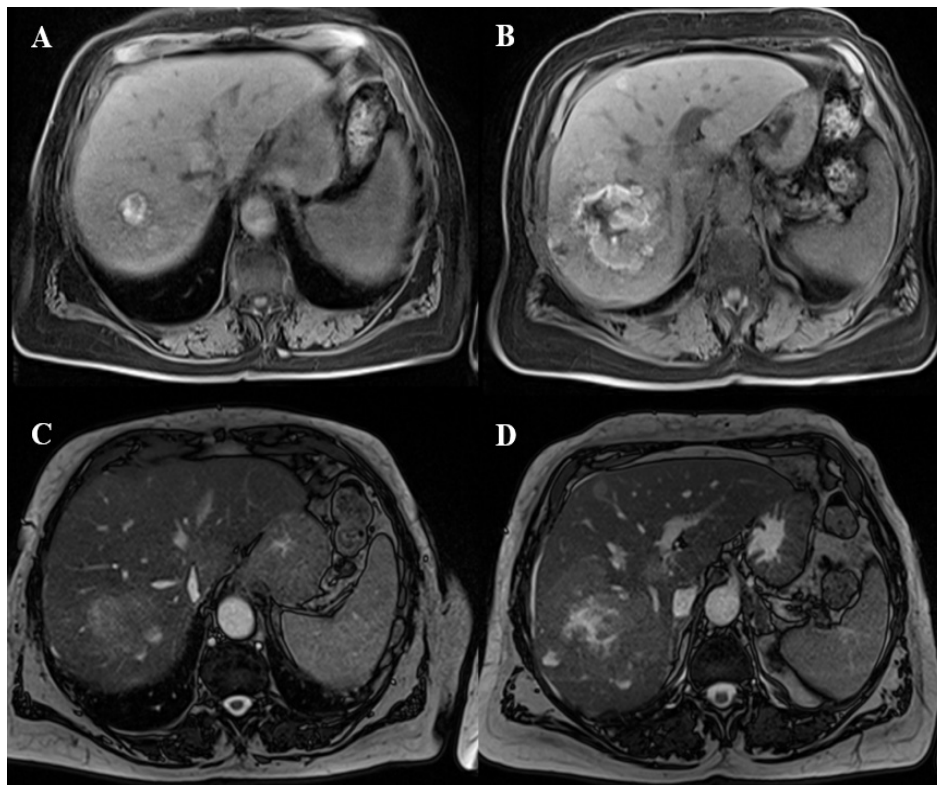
Hepatic lesions with high signal intensity on T1-weighted sequences (A, B), with central hyperintensity on T2-weighted sequences (C, D), consistent with melanin-containing metastases.
